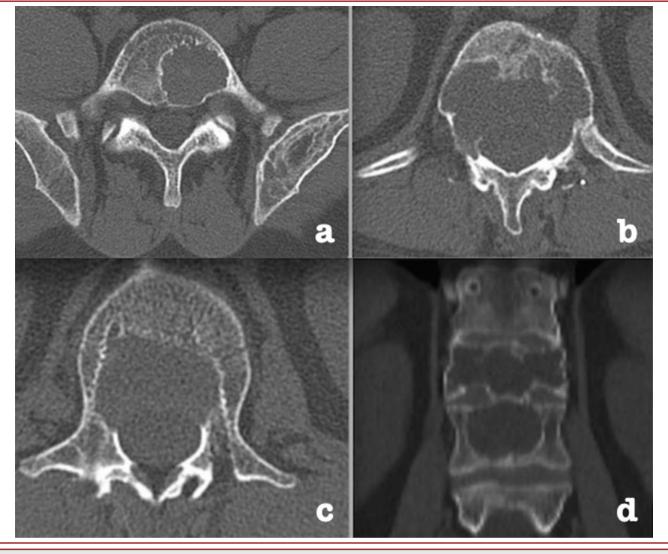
Axial and coronal CT images revealing a) the lesions in L5, b-c-d) T12 - and L1 vertebrae.
